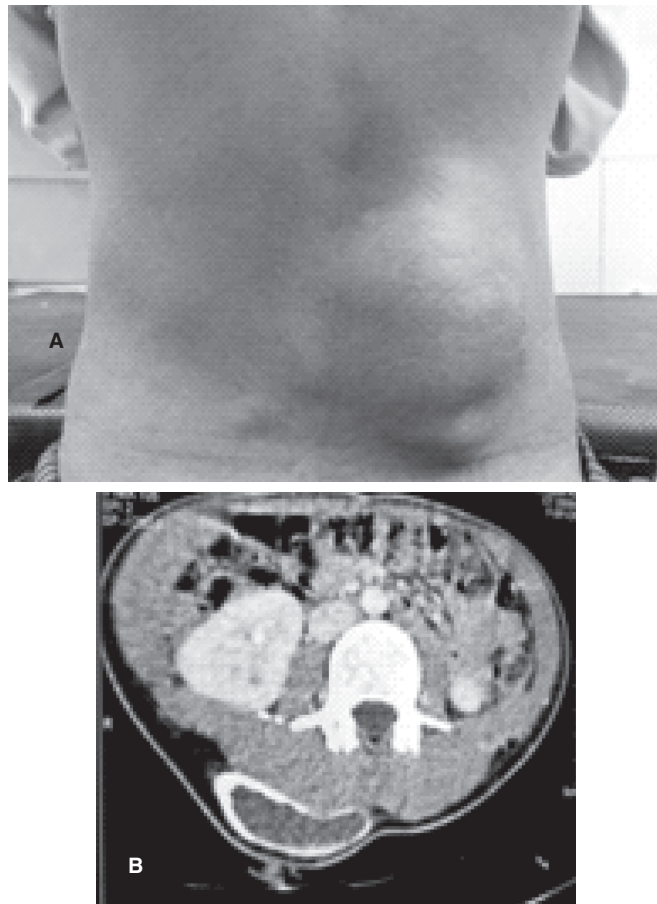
Clinical photograph of back of the child showing a large swelling. B. CT scan of the trunk showing a cyst with calcification of the wall
